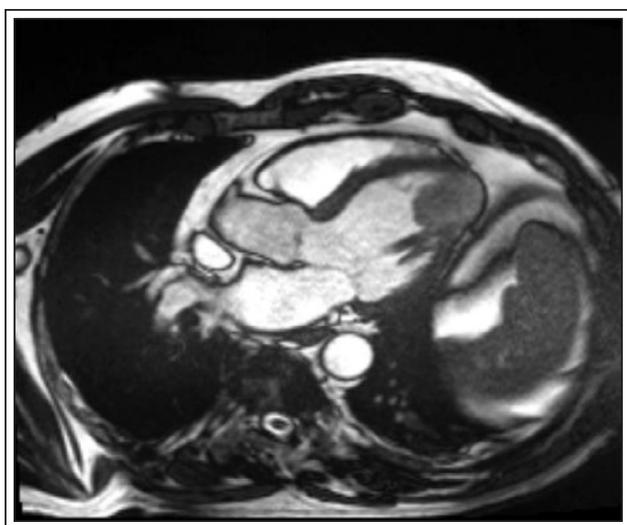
Cardiac MRI revealing a 4.3 cm x 2.6 cm x 2.0 cm lobulated mass emanating from the apical left ventricular myocardium. The mass displays brisk internal enhancement and exuberant delayed enhancement.
